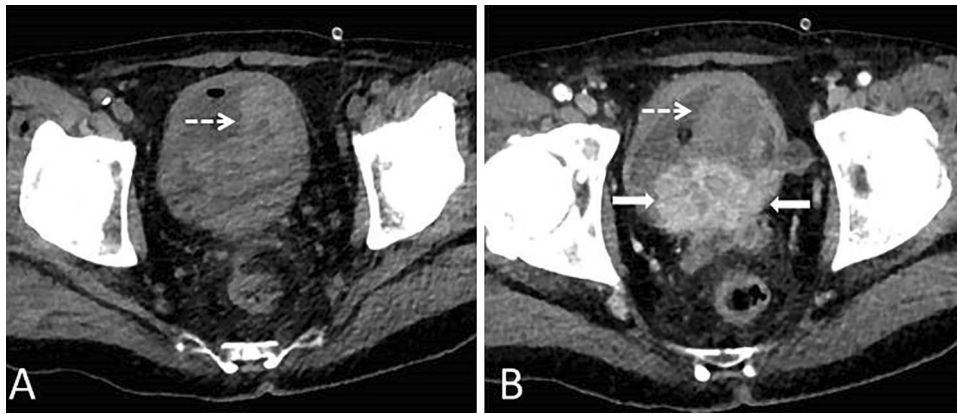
70-year-old male patient presenting with acute onset gross hematuria underwent a CTU examination. A Axial precontrast CT image shows hyperdense structure within the bladder lumen (dashed arrow), suggestive of hematoma. B Axial postcontrast CT image
